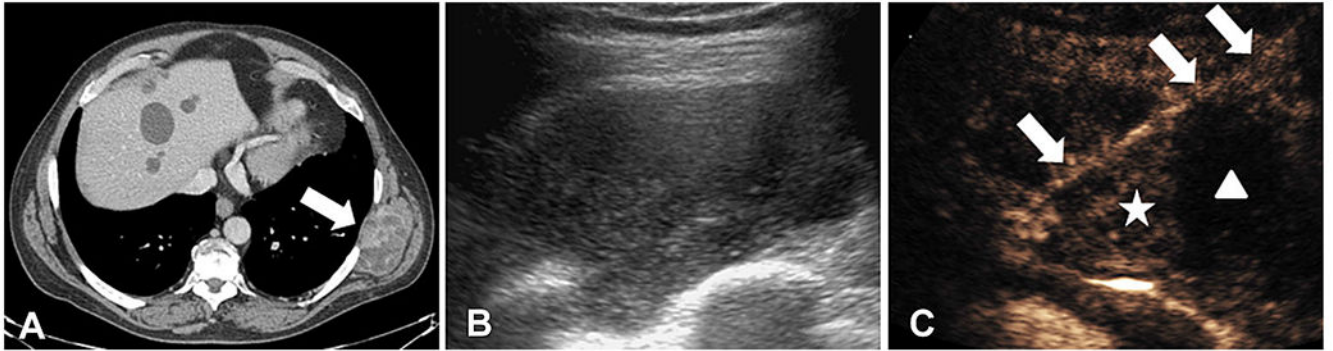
Contrast-enhanced biopsy guidance. (A) Contrast-enhanced CT scan showing an enlarging $8 \times 4 \times 5$ cm left flank mass (arrow) in the setting of known stable metastatic melanoma. (B) Gray-scale ultrasound demonstrating a $8 \times 4 \times 5$ cm complex hypoechoic lesion. (C) Contrast-enhanced ultrasound of the same lesion showing clear areas of perfusion (star) and lack of perfusion. The biopsy needle is depicted (arrow), passing through an area of perfused lesion (star). Areas of poor enhancement (triangle) represent hypo-perfused or necrotic regions of the lesion that may be less likely to provide a definitive diagnosis.
